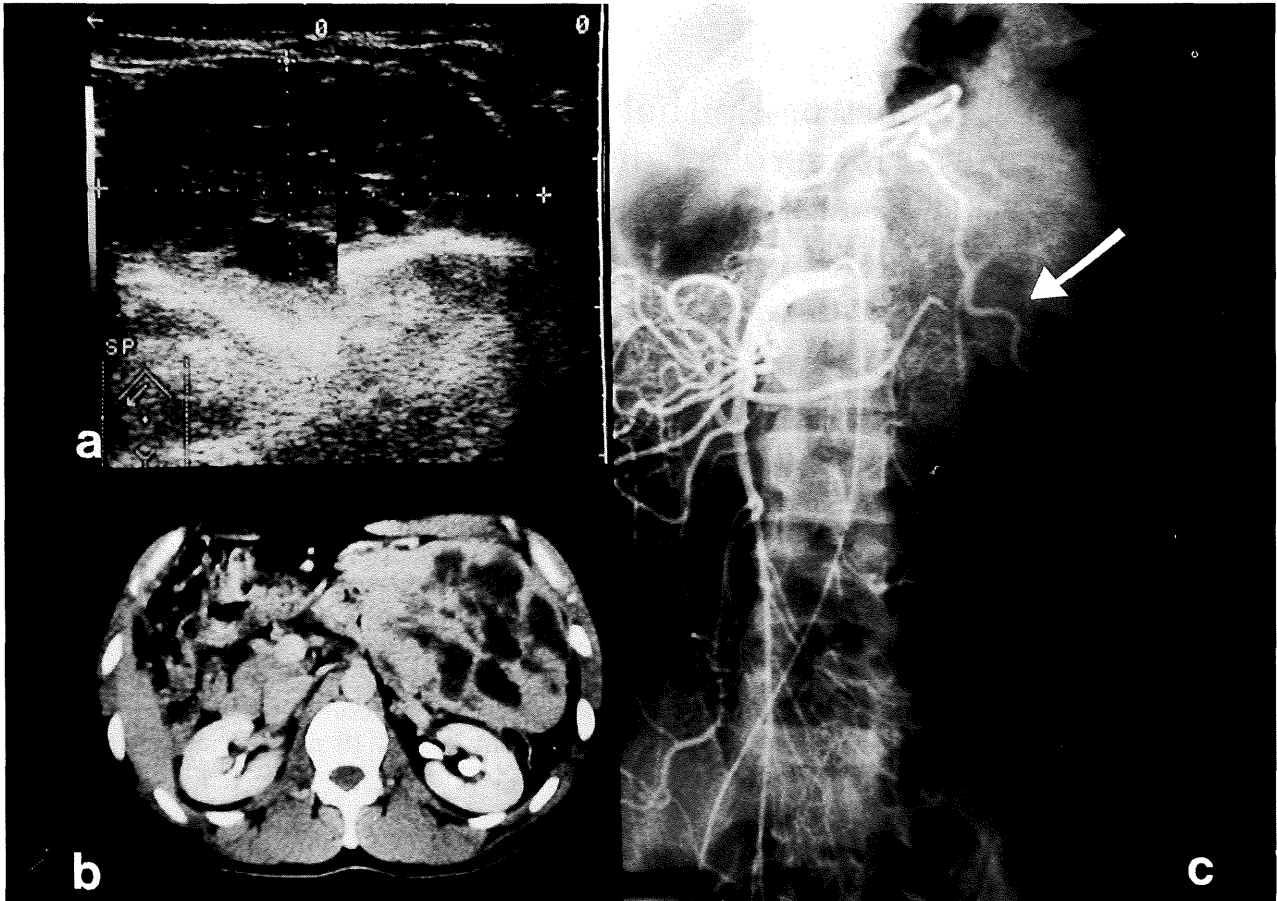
Abdominal ultrasonography showed a mass of 6 cm by 7cm in size, located above the pancreas.
